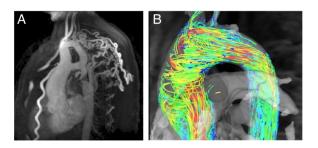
The aorta using cardiac MRI (CMR). (A) A contrast MR angiogram showing critical coarctation and very dilated thoracic collateral vessels. (B) A four-dimensional CMR flow image showing very helical flow in the ascending aorta in a patient with a bicuspid aortic valve.
